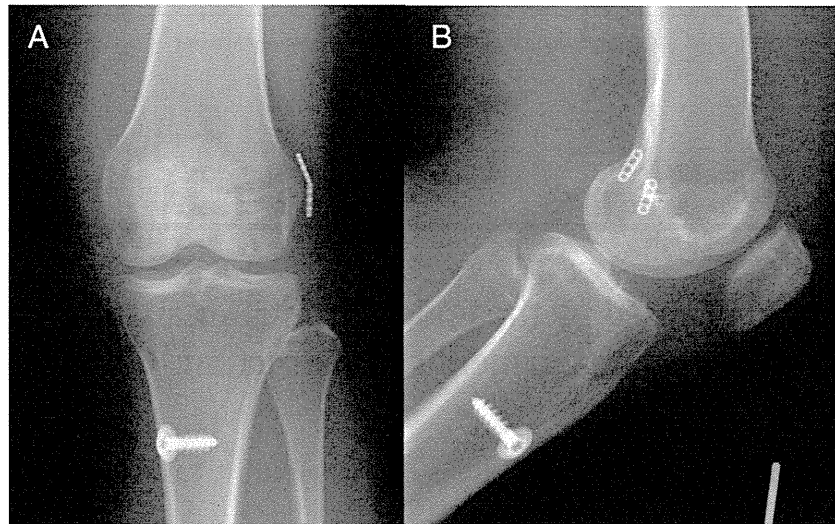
Anteroposterior (A) and lateral (B) radiographs of Case 1 obtained after anatomic anterior cruciate ligament reconstruction showing two EndoButtons. The EndoButton for the anteromedial bundle was in contact with the lateral femoral cortex, while that for the posterolateral bundle was 1 mm off the surface of the lateral femoral cortex with soft tissue interposition.
